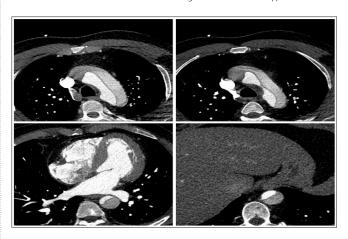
CT Thorax with contrast. The true lumen of the aorta and its branches show high attenuation from contrast as they descend down to the thorax. The dissecting flap surrounds externally the ascending and descending aorta at the level of aortic arch (top images). The dissection extends to the descending and thoracic aorta up to the level of the diaphragm (bottom right image).
